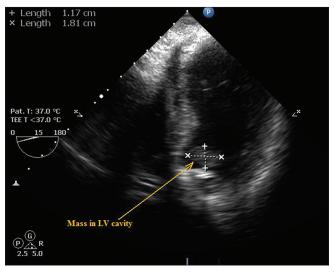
Transgastric short axis view of transsophageal echocardiography view lunar module mass
